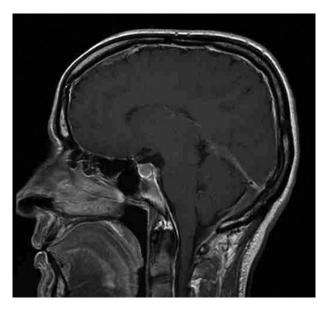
Post-gadolinium, sagittal T1-weighted MRI shows enhancement of meninges.
